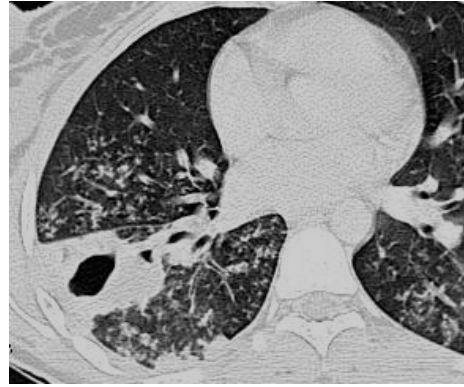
Axial CT, lung window at the level of the ventricles reveal focal cavitating lesion at the anterior basal segment of lower lobe of right lung. The adjacent parenchyma shows fluid filled alveoli proved to be necrotizing pneumonia.
